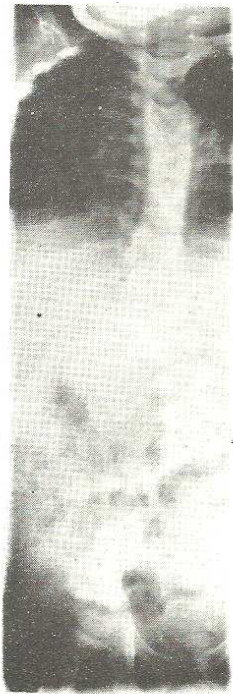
Radiograph of the spine showing hemi-vertebrae involving D10-12 and L1.
